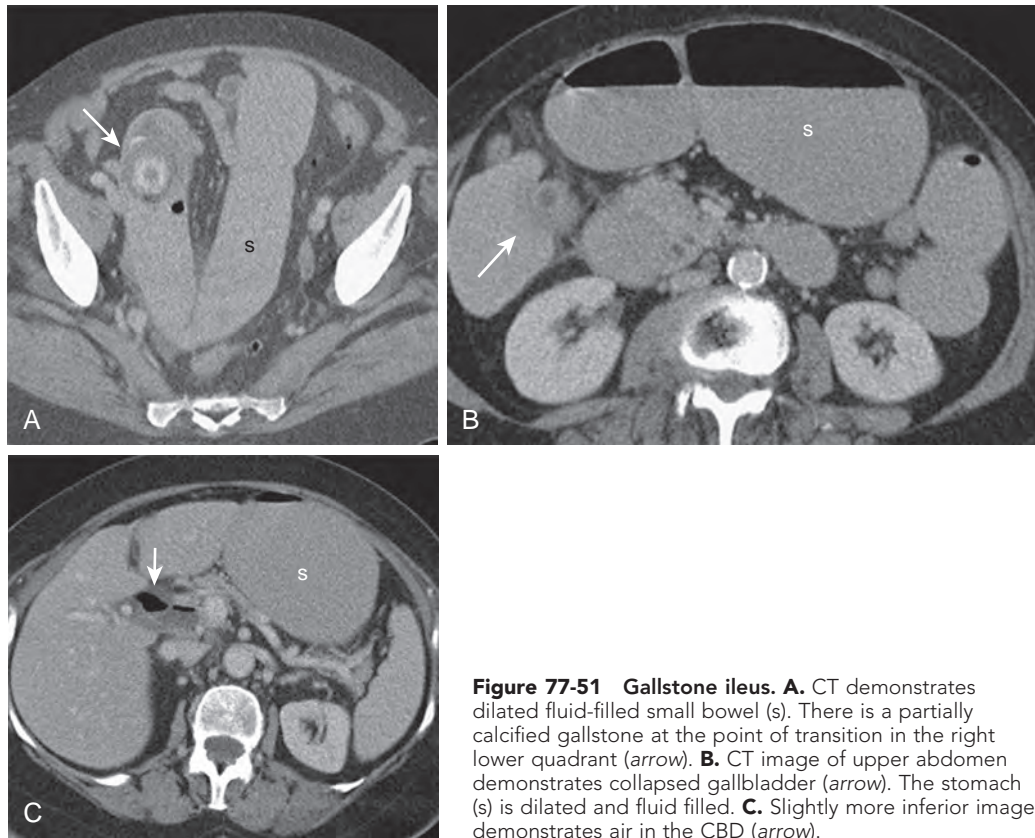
Gallstone ileus. A. CT demonstrates dilated fluid-filled small bowel (s). There is a partially calcified gallstone at the point of transition in the right lower quadrant (arrow). B. CT image of upper abdomen demonstrates collapsed gallbladder (arrow). The stomach (s) is dilated and fluid filled. C. Slightly more inferior image demonstrates air in the CBD (arrow).
